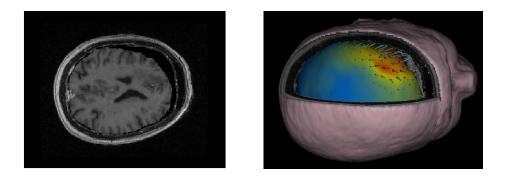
Left : preoperative MR image registered on the intraoperative image. Right: 3D view of the brain deformation
